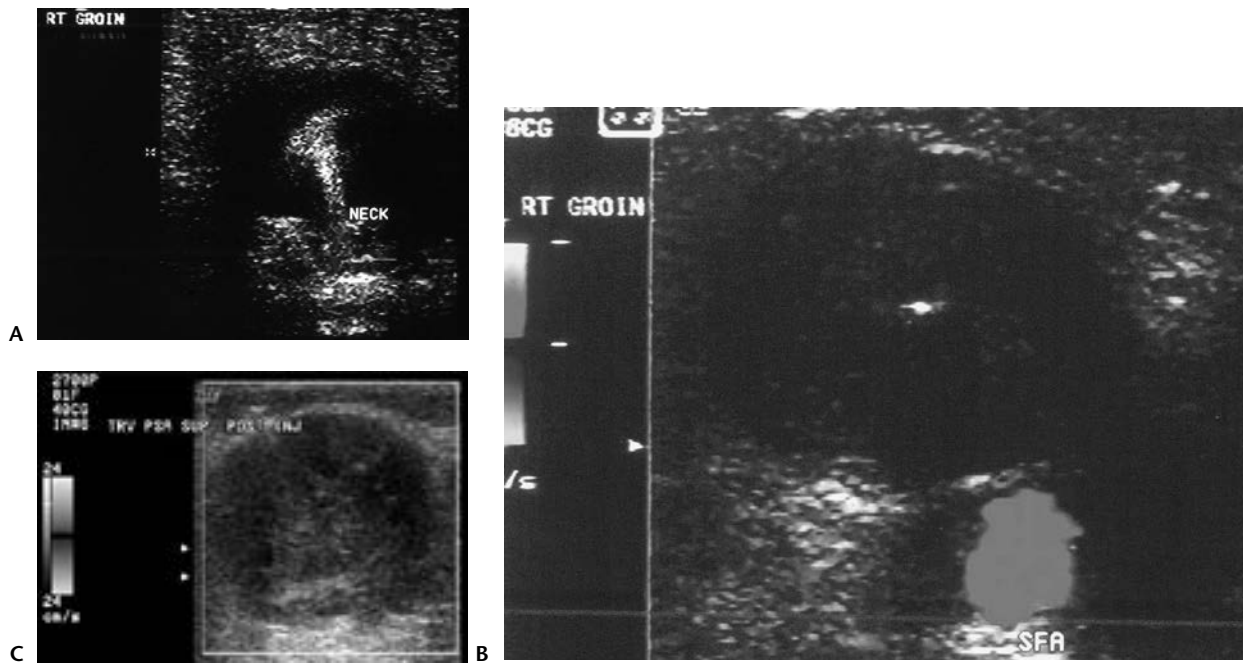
Arterial pseudoaneurysm. A: B flow duplex image of a pseudoaneurysm at the time of diagnosis. B: The hyperechoic needle tip in the center of the pseudoaneurysm at the time of thrombin injection. C: The ultrasonographic appearance of the thrombus in the successfully thrombosed pseudoaneurysm.
